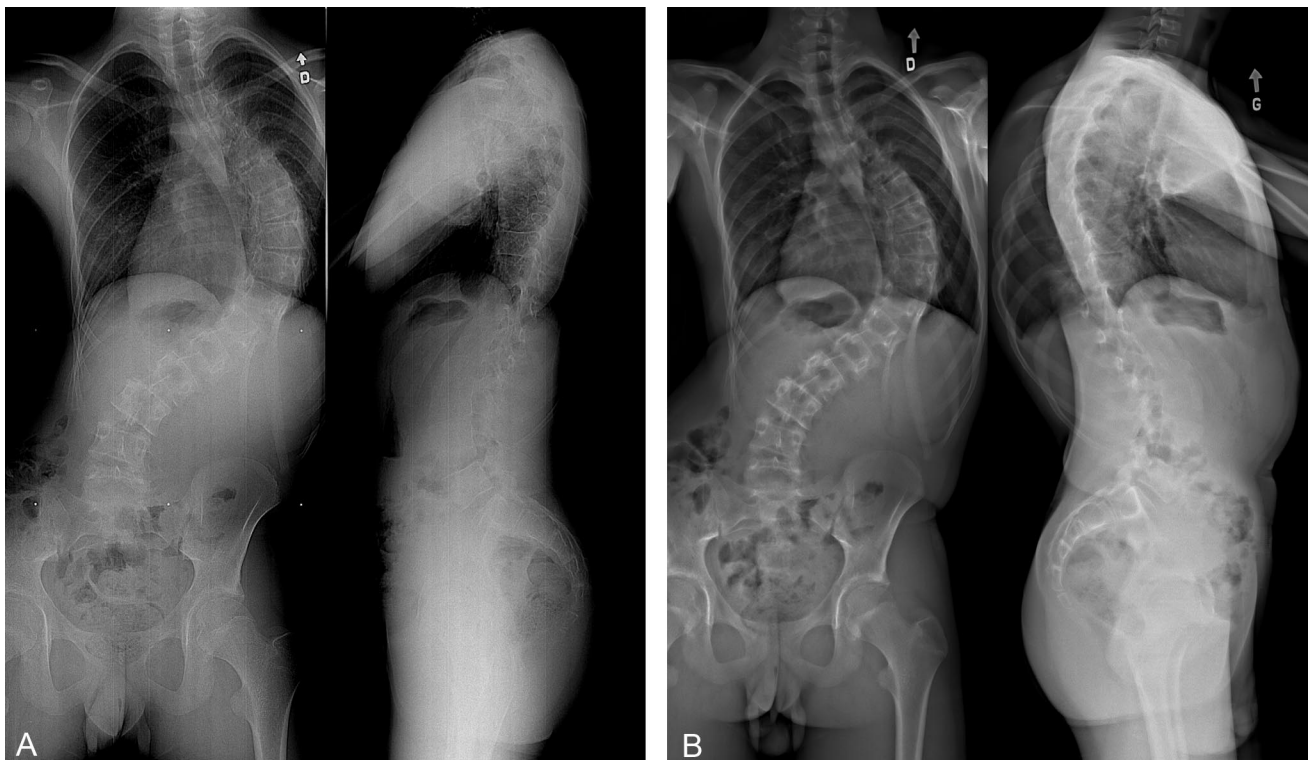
A, Posteroanterior and lateral view of a patient taken with the CR system and (B) radiographs of the same patient acquired by the slot-scanner.
